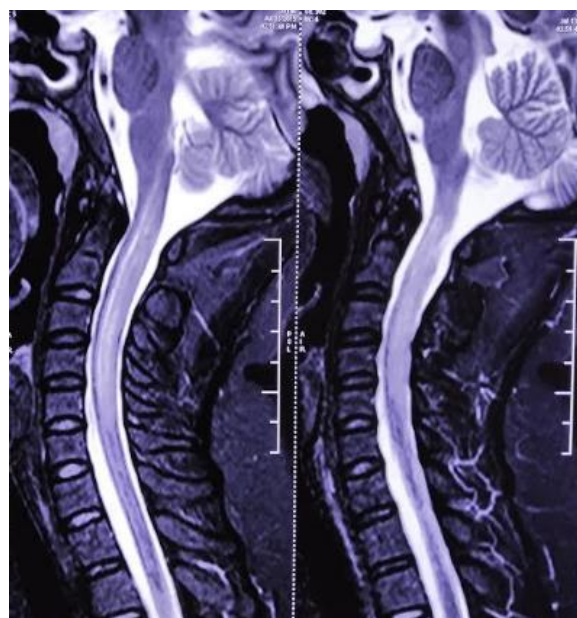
MRI spine T2 sagittal sections showing intramedullary hyperintensity extending from cervicomedullary junction to fifth cervical vertebra.
